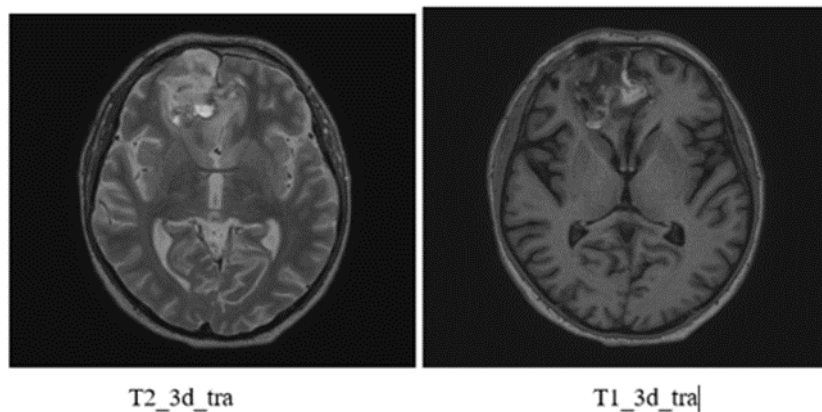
MRI after surgical treatment
